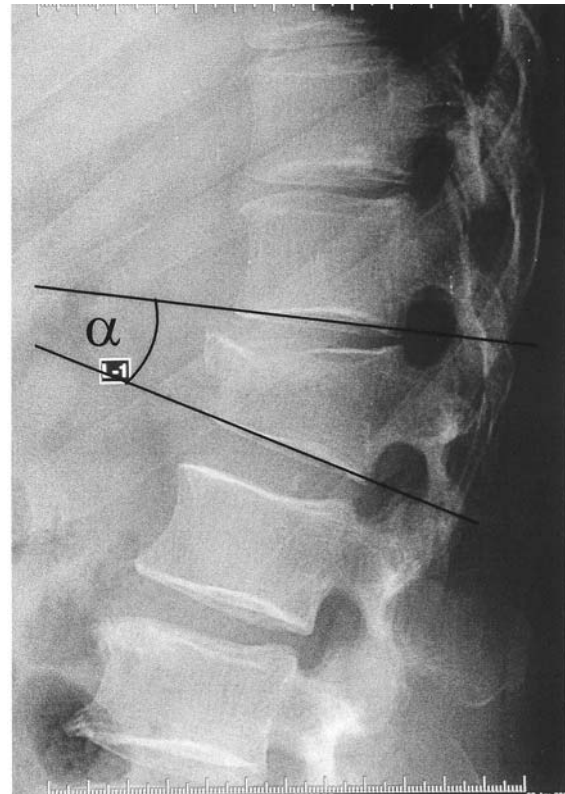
Local Kyphosis angle (assessed on the lateral radiograph by measuring the angle obtained by a line parallel to the inferior endplate of the fractured vertebra and that of the vertebra one level above)
